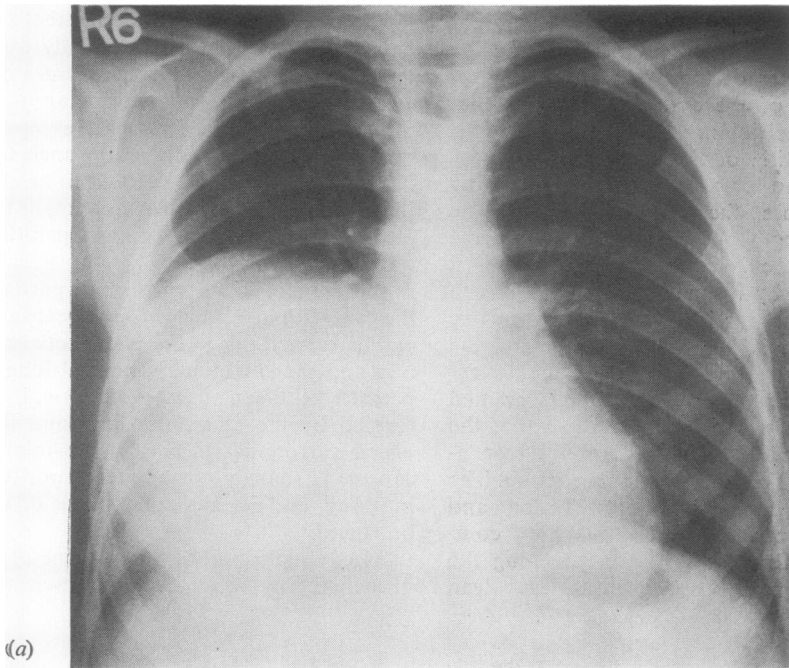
Case 1. PA (a) and lateral (b) radiographs showing a 12 cm pulmonary hydatid cyst in a child aged 7 years.*
